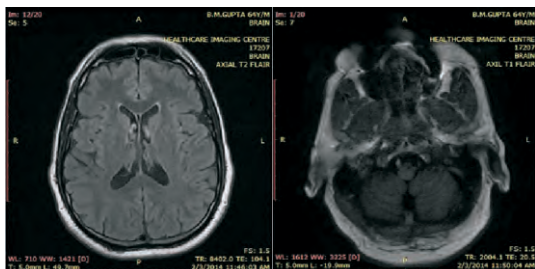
b : MRI Brain- no pathology detected in basal ganglion.
